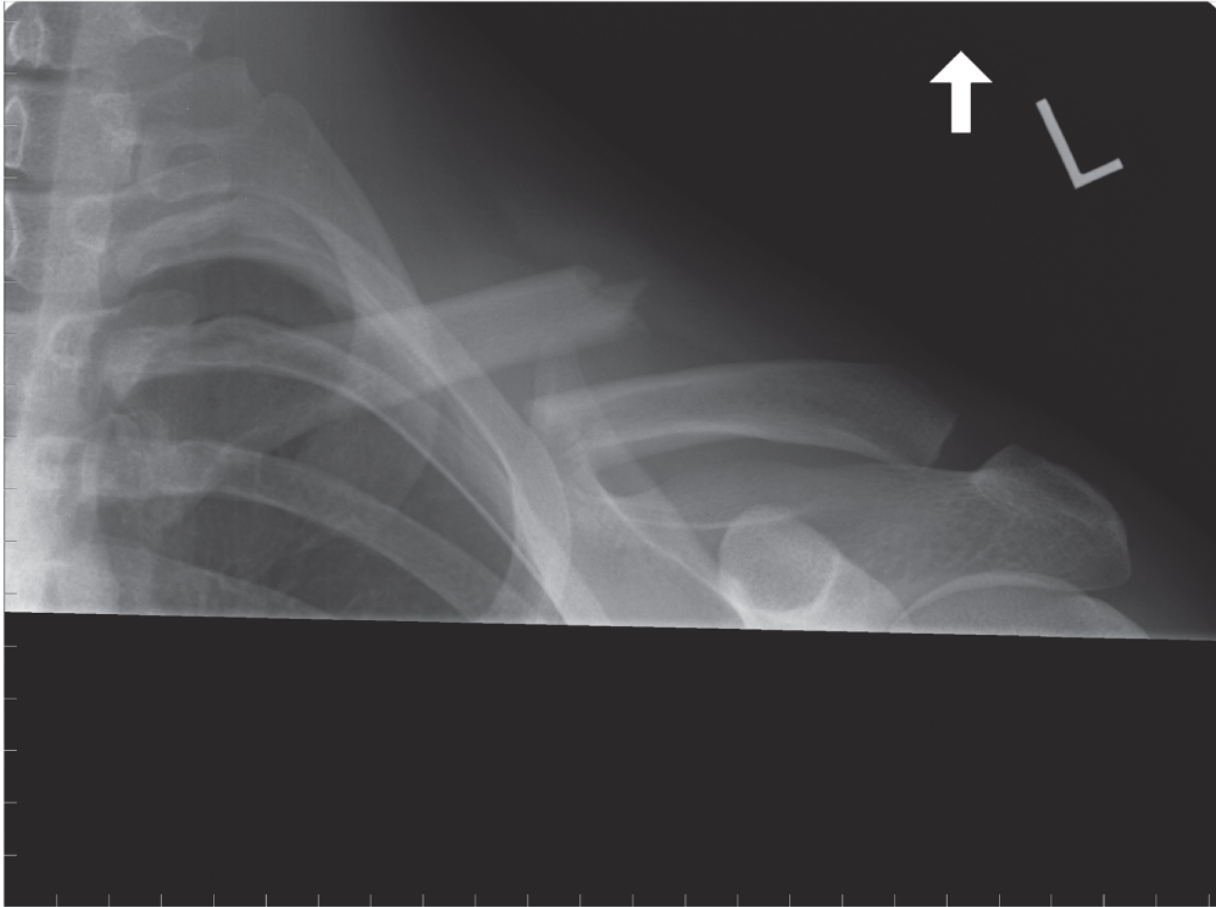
Radiograph of a 30-year-old man who fell off his mountain bike and sustained a midshaft clavicle fracture. Displacement and shortening is evident.
